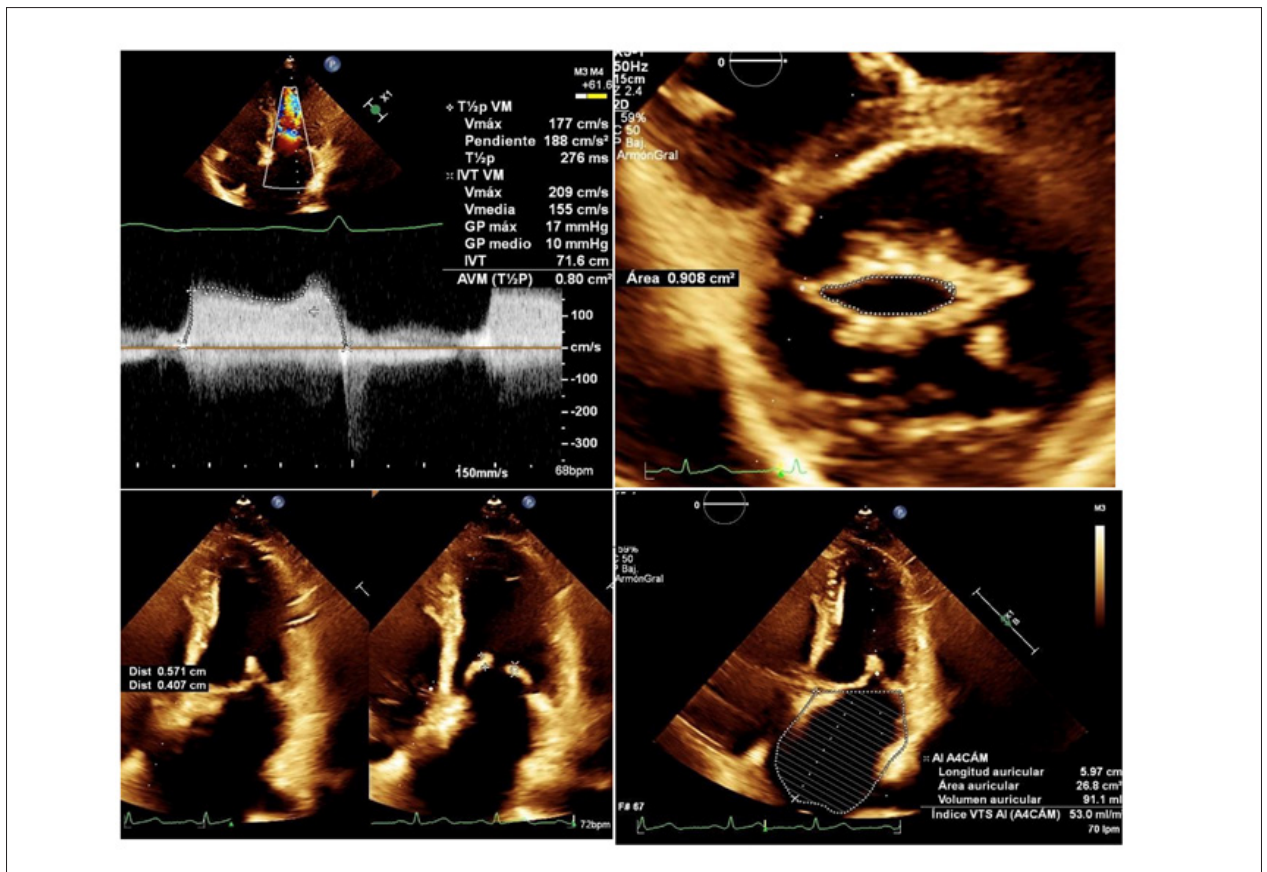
TTE with mitral Doppler shows a pressure half-time of 276 ms and an estimated valve area of 0.8 cm² (Image A). Planimetry measures a valve area of 0.9 cm² (Image B). Thickened mitral valve with rheumatic changes (Image C). Severely dilated left atrium with a volume of 91 ml (Image D).
